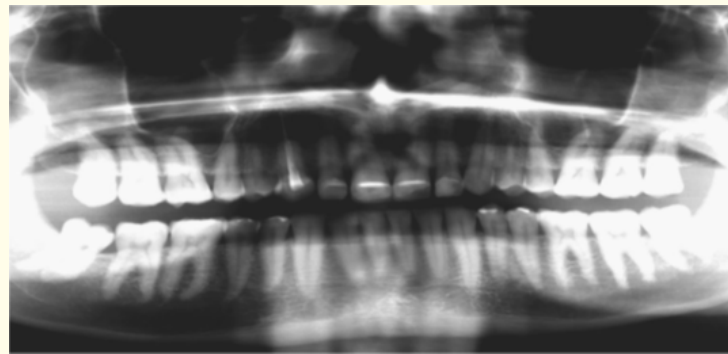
Showing initial radiographic analysis using the panoramic view [11].
